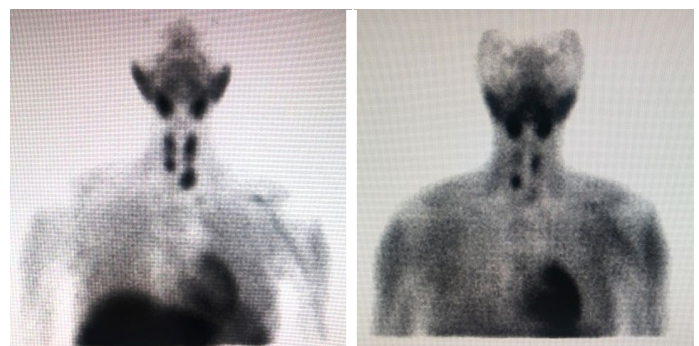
Tc-99m MIBI parathyroid scintigraphy images showing 4 parathyroid adenomas before surgery.
